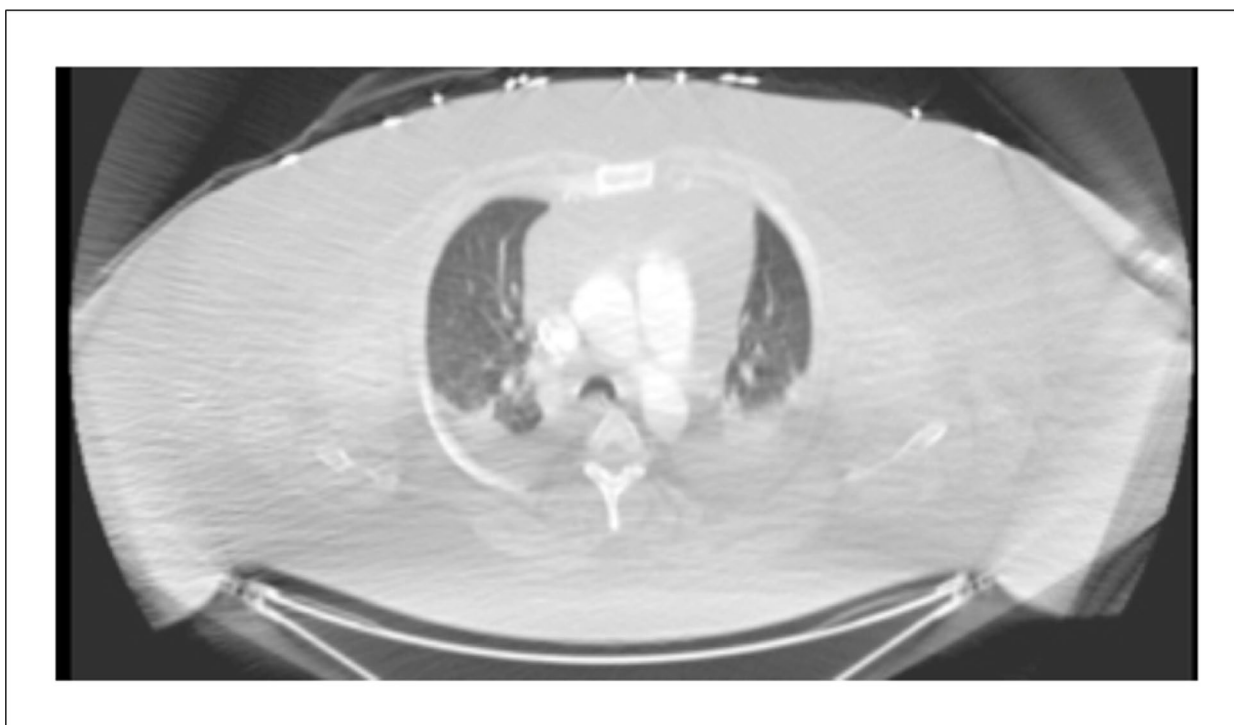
Axial chest computed tomography image obtained in an intubated and mechanically ventilated patient with severe obesity (BMI 92 kg/m²). The image was obtained at the level of the tracheobronchial carina. It demonstrates markedly reduced aerated lung volumes with extensive bilateral dependent (posterior) atelectasis. The cardiac silhouette occupies more than half of the maximal transverse thoracic diameter, reflecting markedly reduced intrathoracic space available for lung expansion. These anatomical features likely contribute to increased superimposed pressure on dependent lung regions and reduced functional lung volume
